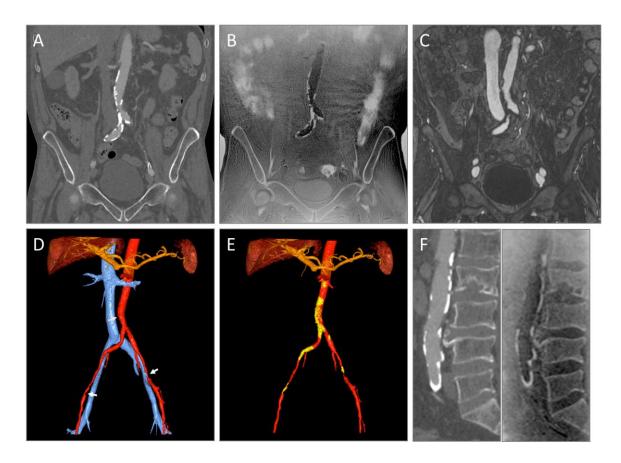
Coronal views of CTA, FeMRA and StarVIBE.
